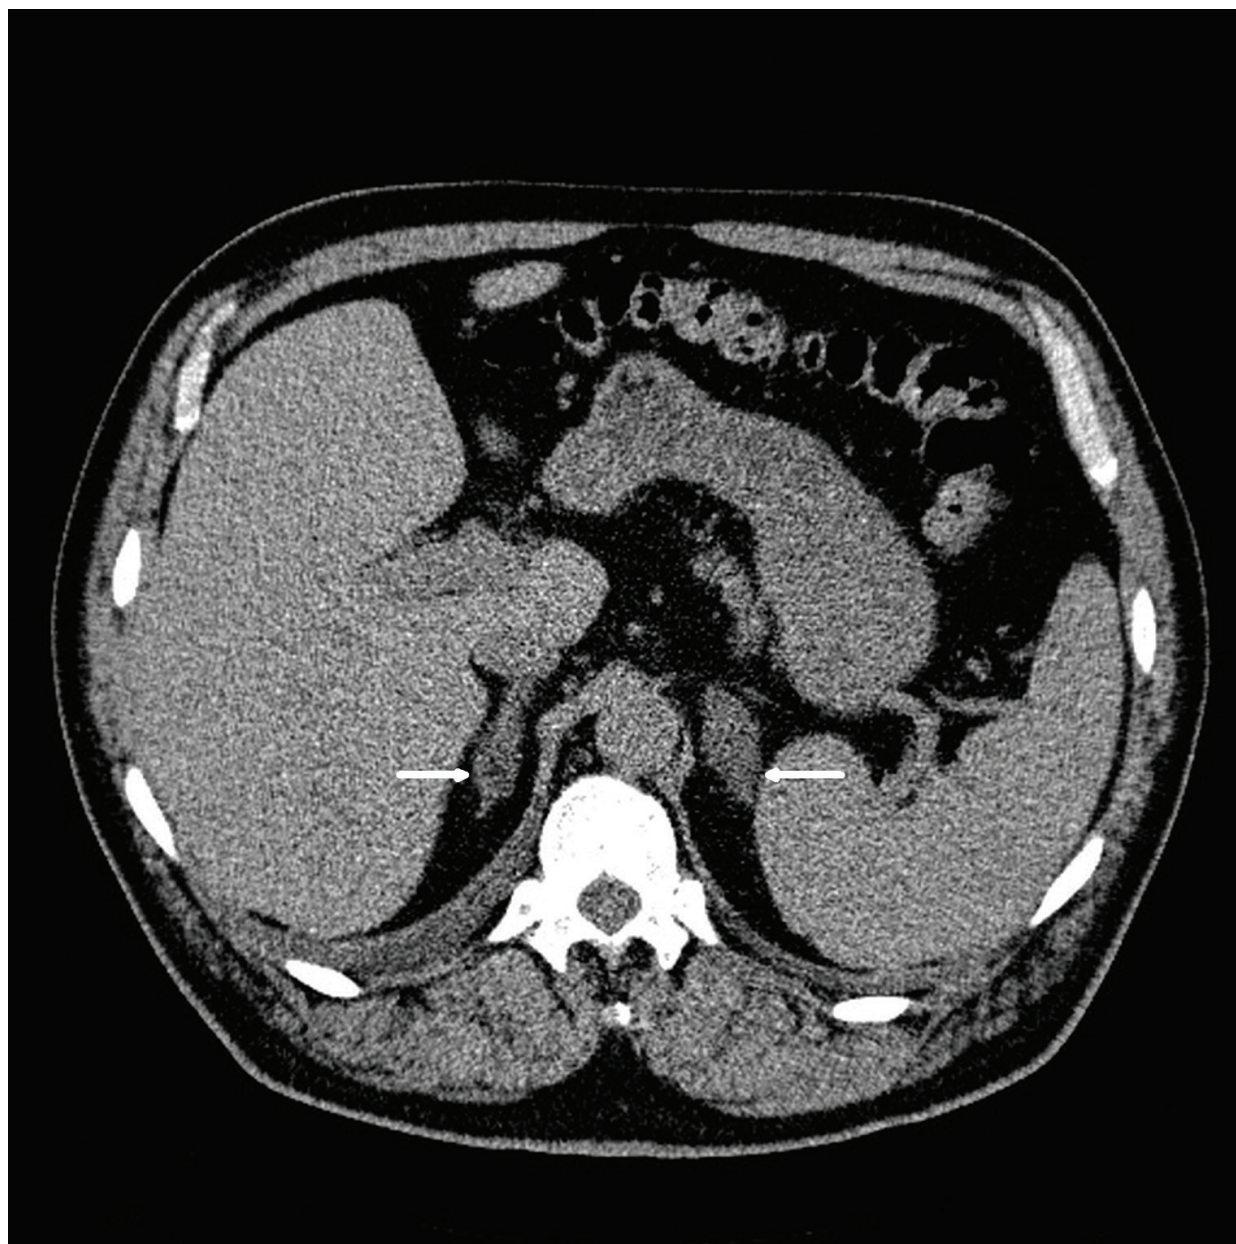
Bilaterally enlarged adrenal glands with aldosterone-producing adenoma (20 mm) on the right and hormonally inactive incidentaloma (30 mm) on the left (arrows) (CT scan).
